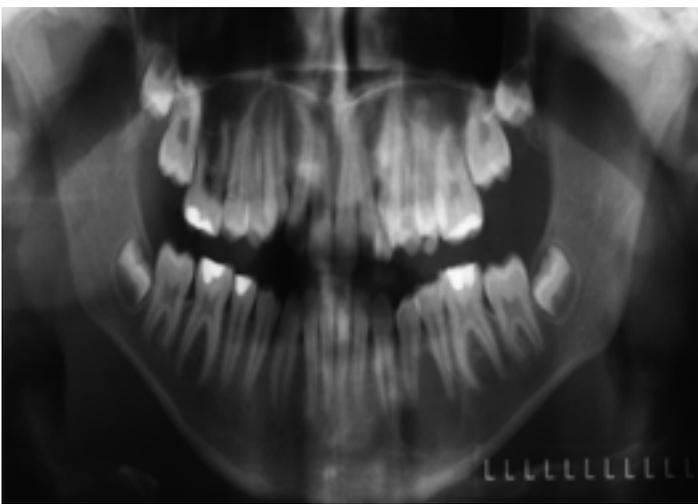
Panoramic radiograph taken before orthodontic treatment revealed an incidental finding of a large osteolytic lesion of the area of the left lower first and second premolars.
